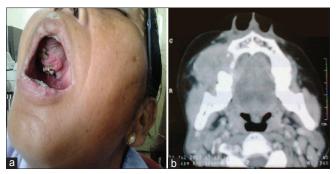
(a) Local examination showing an ulcerated lesion in the right maxillary arch. (b) Computed tomography showing a heterogenous soft tissue mass lesion in the maxilla
